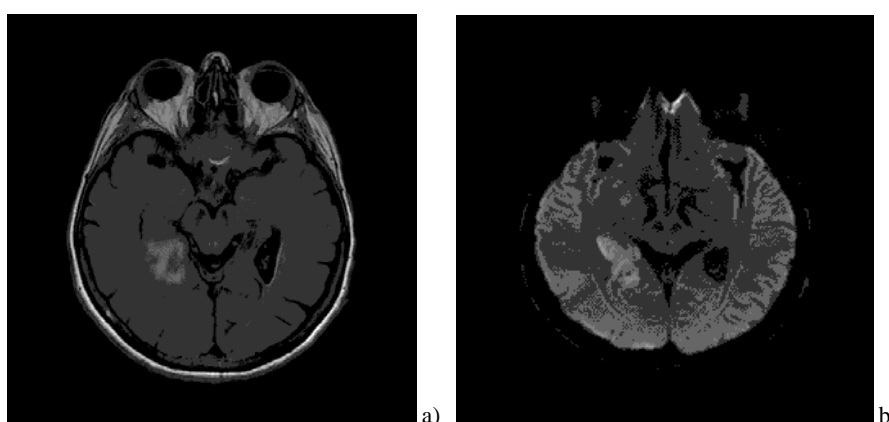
a) T2 fluid-attenuated inversion recovery (FLAIR) shows hyperintensity of the signal in the region of the hippocampus and parahippocampally on the right. On the left side hypointensity in the same region; b) DWI shows diffusion restriction in the hippocampus and parahippocampal gyrus on the right.
